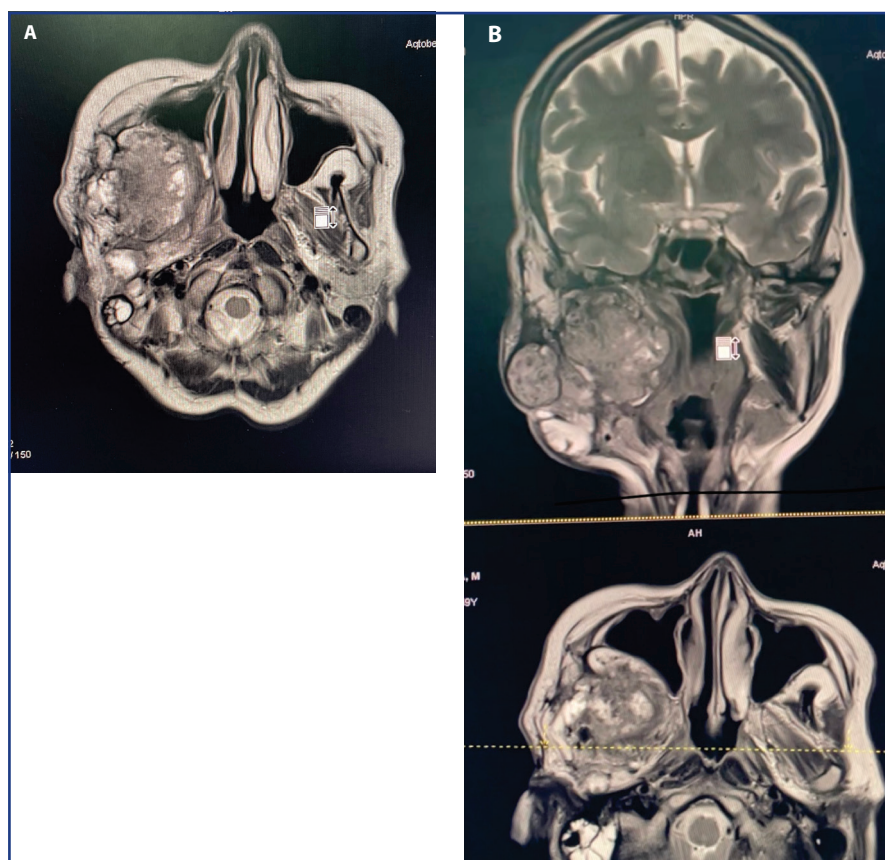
MRI picture of a volumetric formation in the lower jaw in a 63-year-old patient diagnosed with “Ameloblastoma of the mandible. Recurrence: A – axial projection, B – frontal projection.
